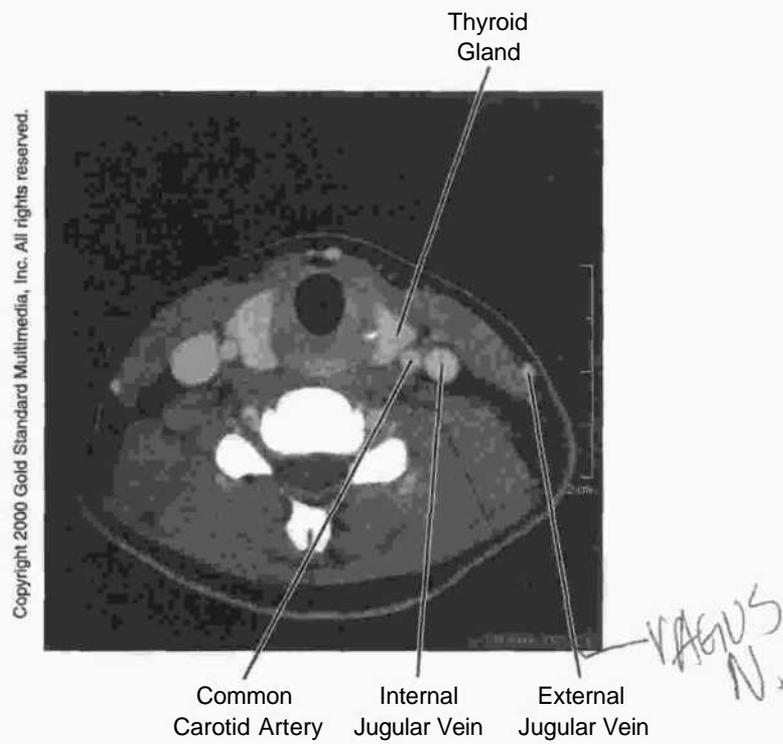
Figure IH-6-27. Head and Neck: CT, Neck at C₅
